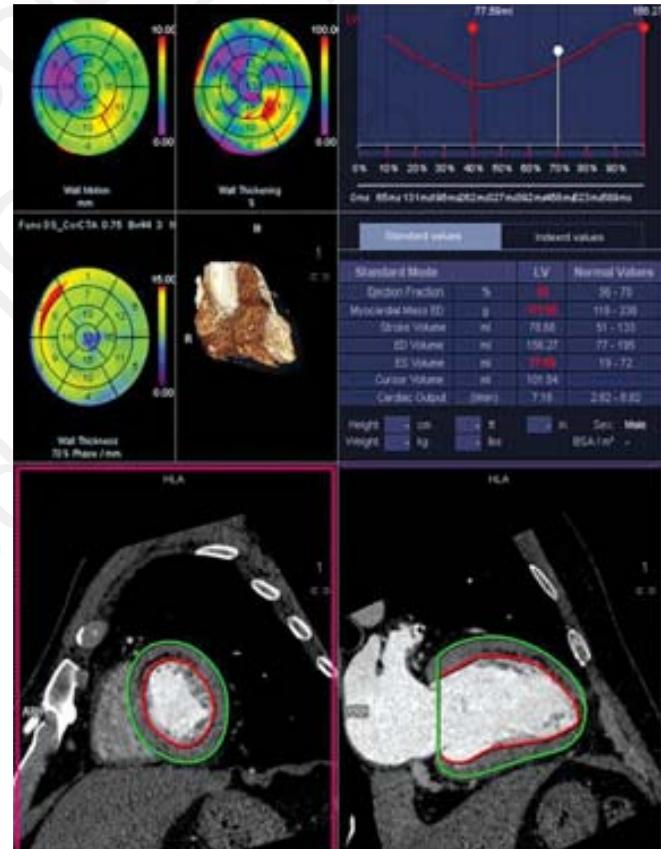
Functional assessment using computed tomography which shows decreased ejection fraction (50%) in a patient earlier ischemic insult. Dark areas of hypoperfusion are seen in the anterior wall of left ventricle myocardium.
